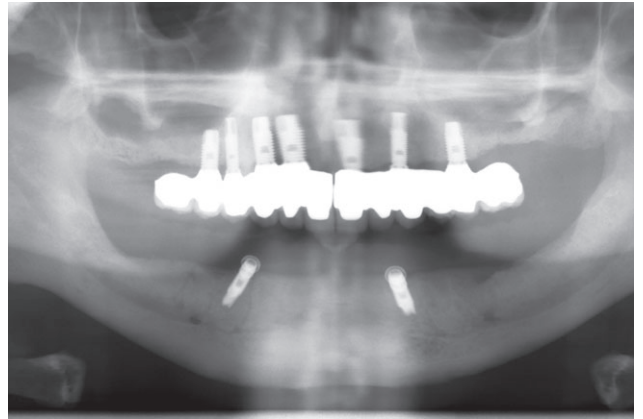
Panoramic radiograph 2 years after insertion of definitive zirconia prostheses.
